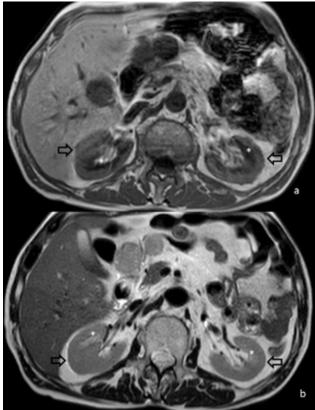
Normal kidney signal at MRI (another patient from the hospital database). T1W image (a) displays normal cortex-medulla differentiation, with the cortex (arrows) appearing more intense than the medulla (*). T2W (b) depicts both medulla (*) and cortex (arrows) normal high signal.
